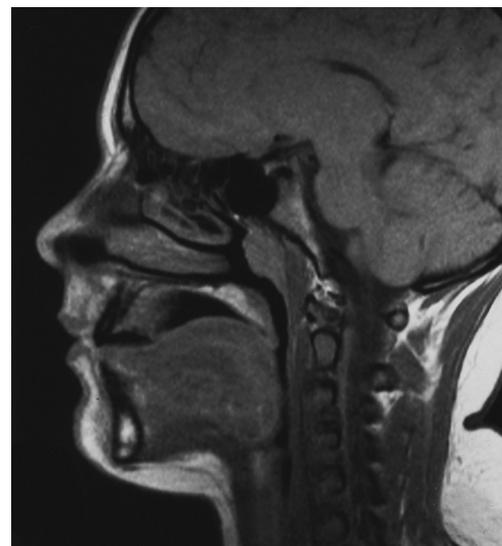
Magnetic resonance image of head and neck.
